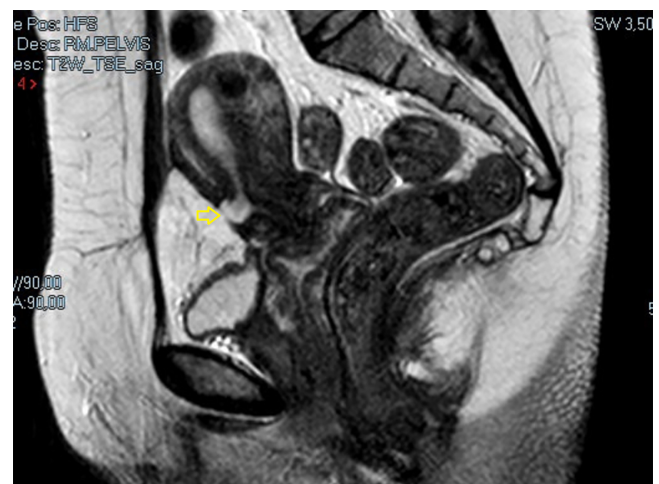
Isthmocele (arrow) as depicted by magnetic resonance imaging.
